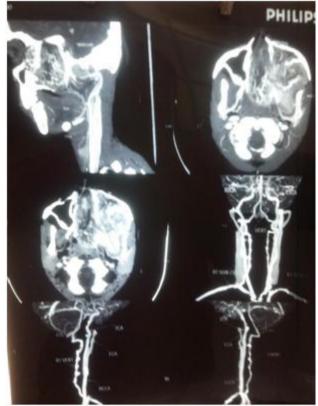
CT angiography image of the patient showing the "feeding vessel" - internal maxillary artery, branch of the external carotid artery.
